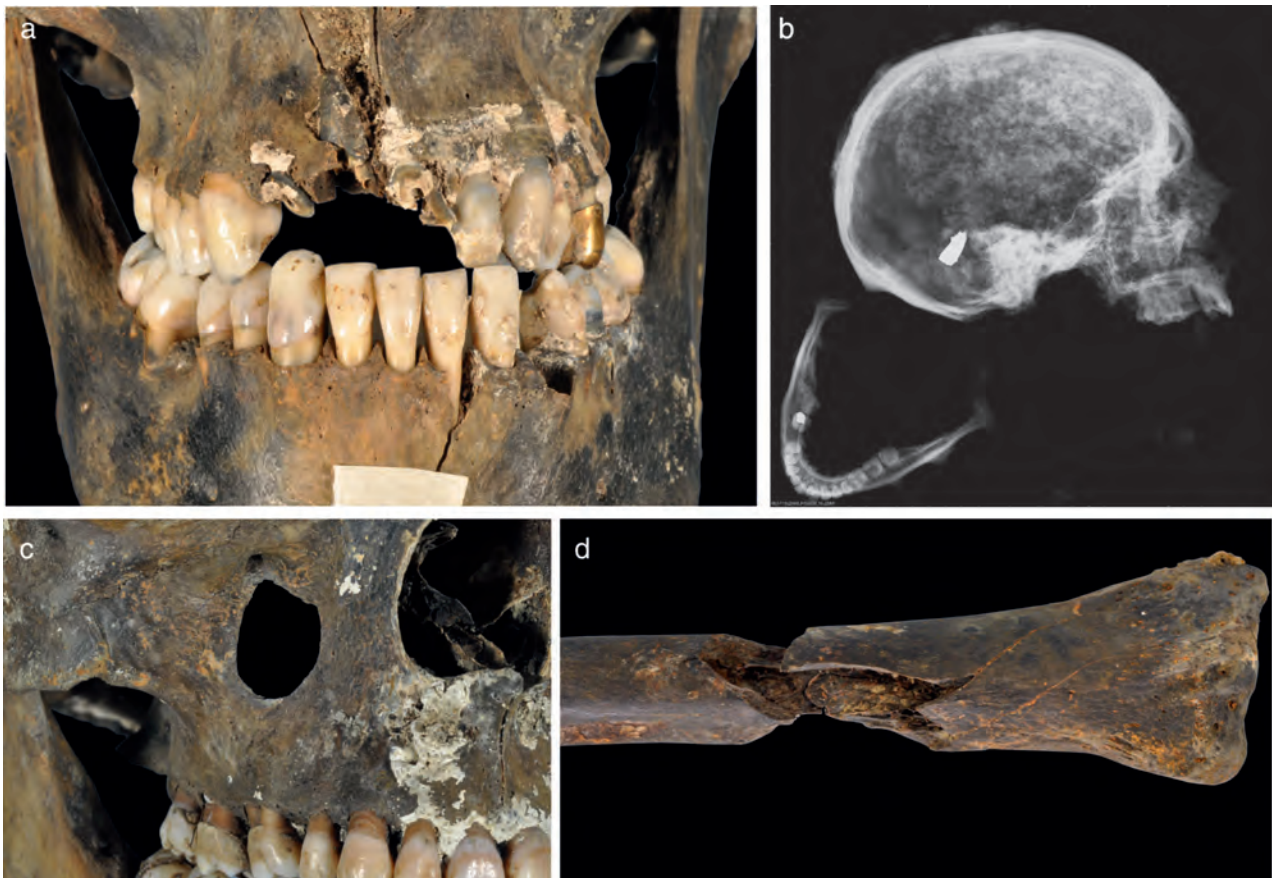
a) Jaw of 2928B: a contorted lead bullet was recovered from the area of tooth loss; b) radiograph of 3091B showing a bullet embedded in the cranial vault; c) circular defect on the right maxilla of 3091B; d) butterfly fracture involving the distal right radius, without involvement of other bones (1872B)
